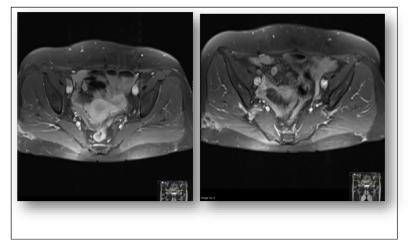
Magnetic resonance imaging (MRI) of ovary.
